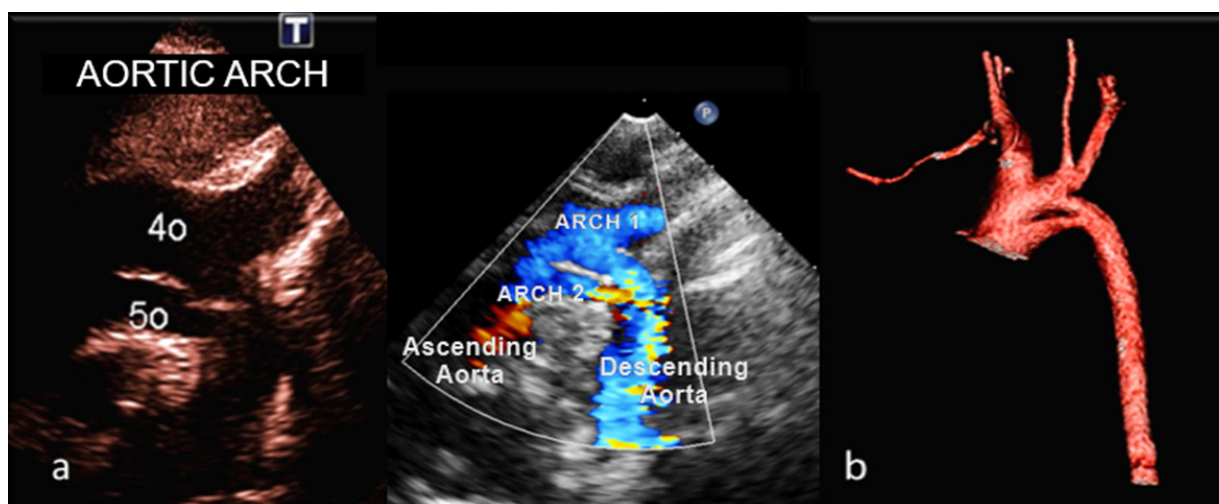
Double-lumen aortic arch: (a) two-dimensional echocardiography in the suprasternal view.
